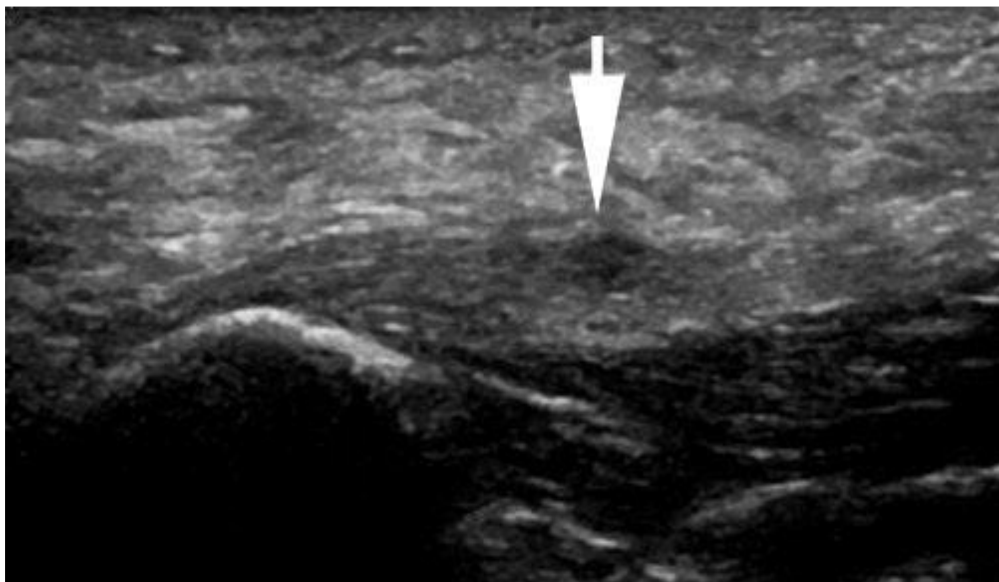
Partial plantar fascia tear seen as a small hypoechoic focus. Image adapted from a study by Claire Filippini, 2019 on Ultrasound features of the sole of foot pathology (14)
